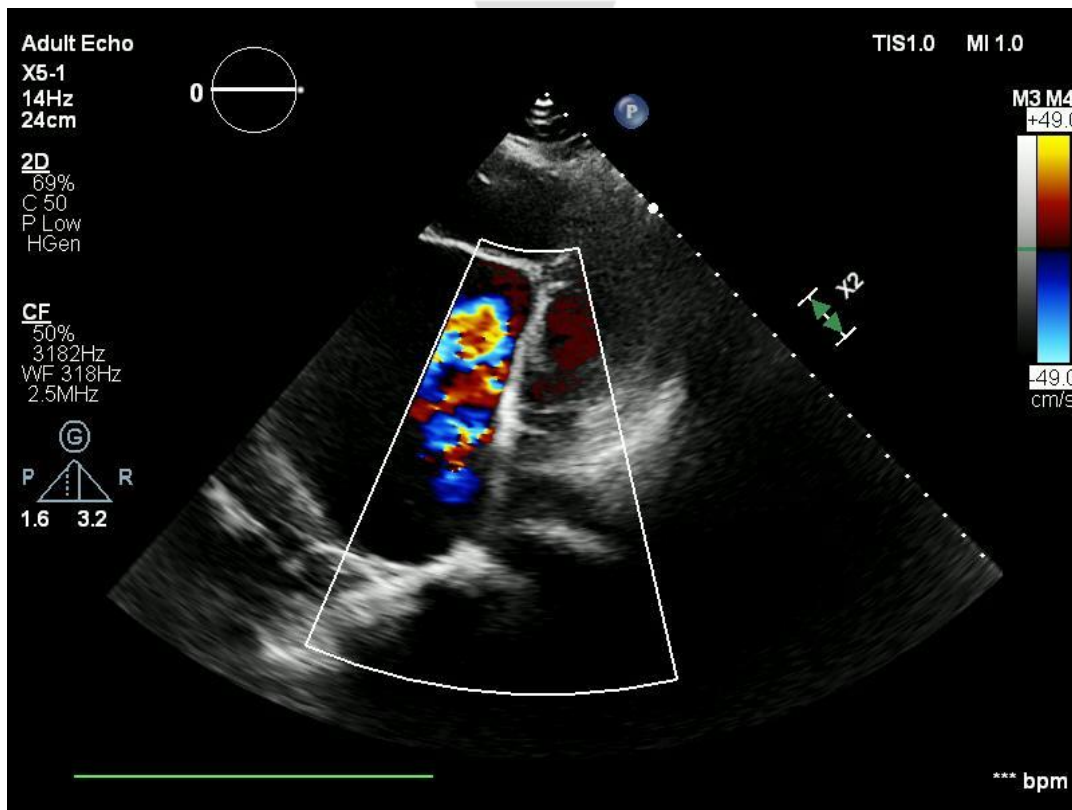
Colour transthoracic ECHO suggestive of severe TRV
